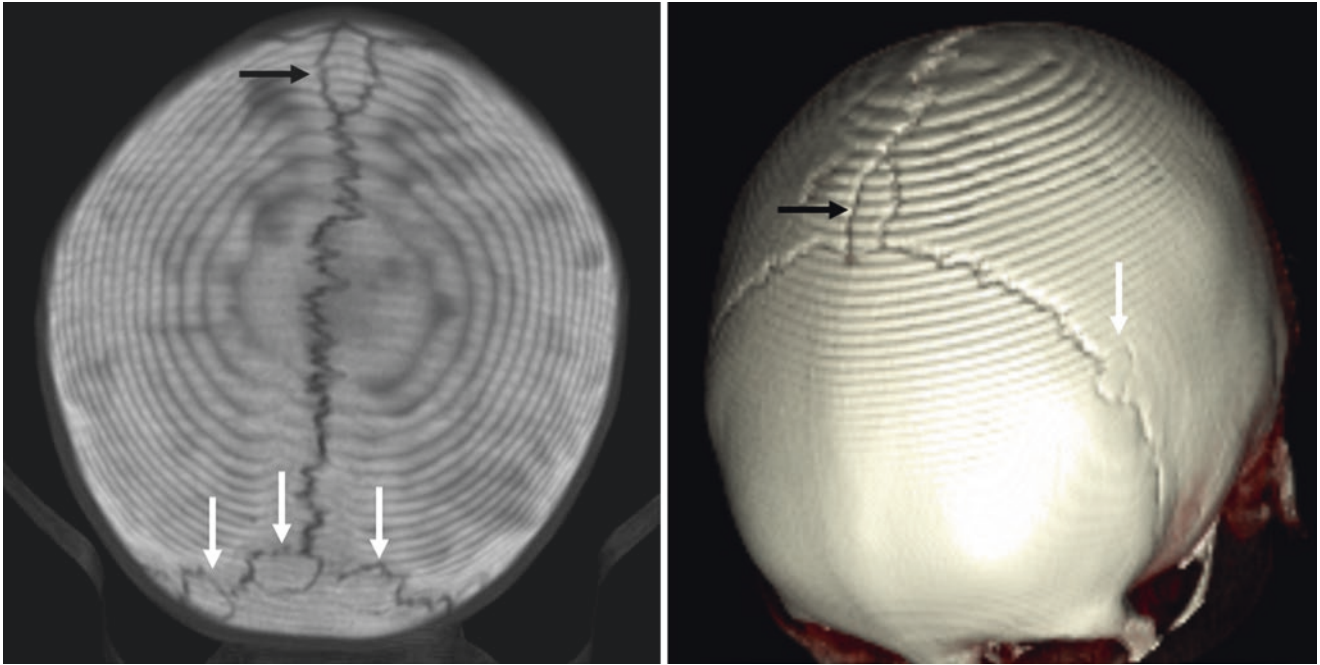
A 7 year old: multiple intrasutural bones (*white arrows*) are depicted on a superior view of a 20-mm thickness MPR (*left*) and on a 3D VR CT (*right, oblique PA view*). One of the intrasutural bones is an
